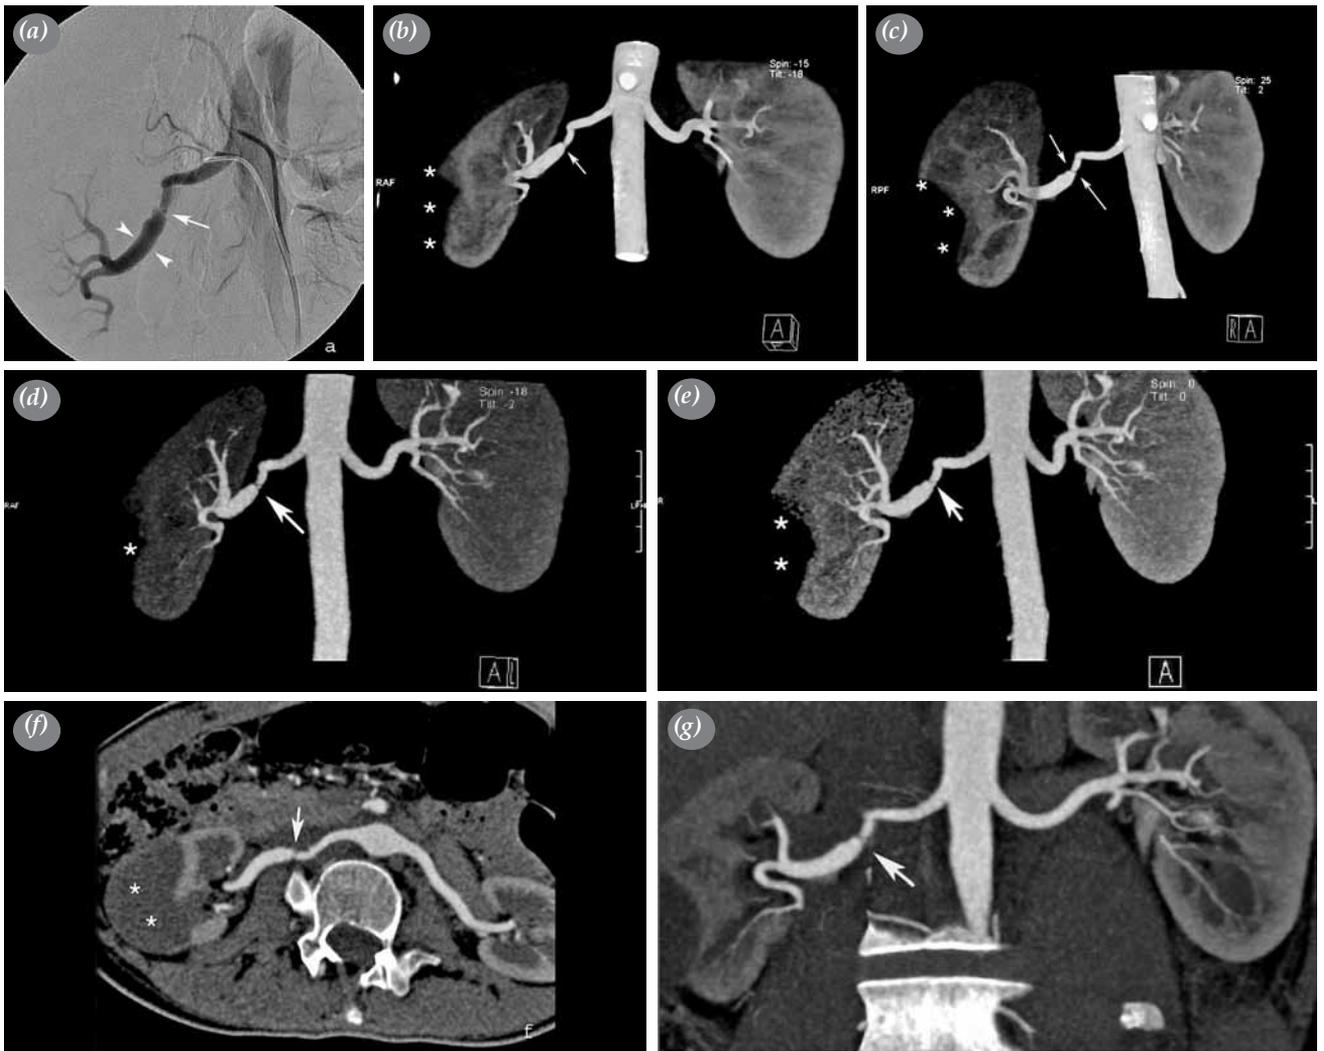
(a) Selective right renal angiogram shows severe stenosis (arrow) in the mid portion of the right main renal artery and post-stenotic dilatation (arrowheads), (b, c) volume rendering technique images show the severe degree of stenosis (arrow), post-stenotic dilatation, and normal left main renal artery, (d, e) Maximum intensity projection images show the severe degree of stenosis (arrow), post-stenotic dilatation, and normal left main renal artery, (f, g) Coronal and axial curved planer reformat images show the severe degree of stenosis (arrow), post-stenotic dilatation, and normal left main renal artery, On all reformatted computed tomography images, there is a cortical defect at the right kidney that may be the result of a sequel (asterix).
